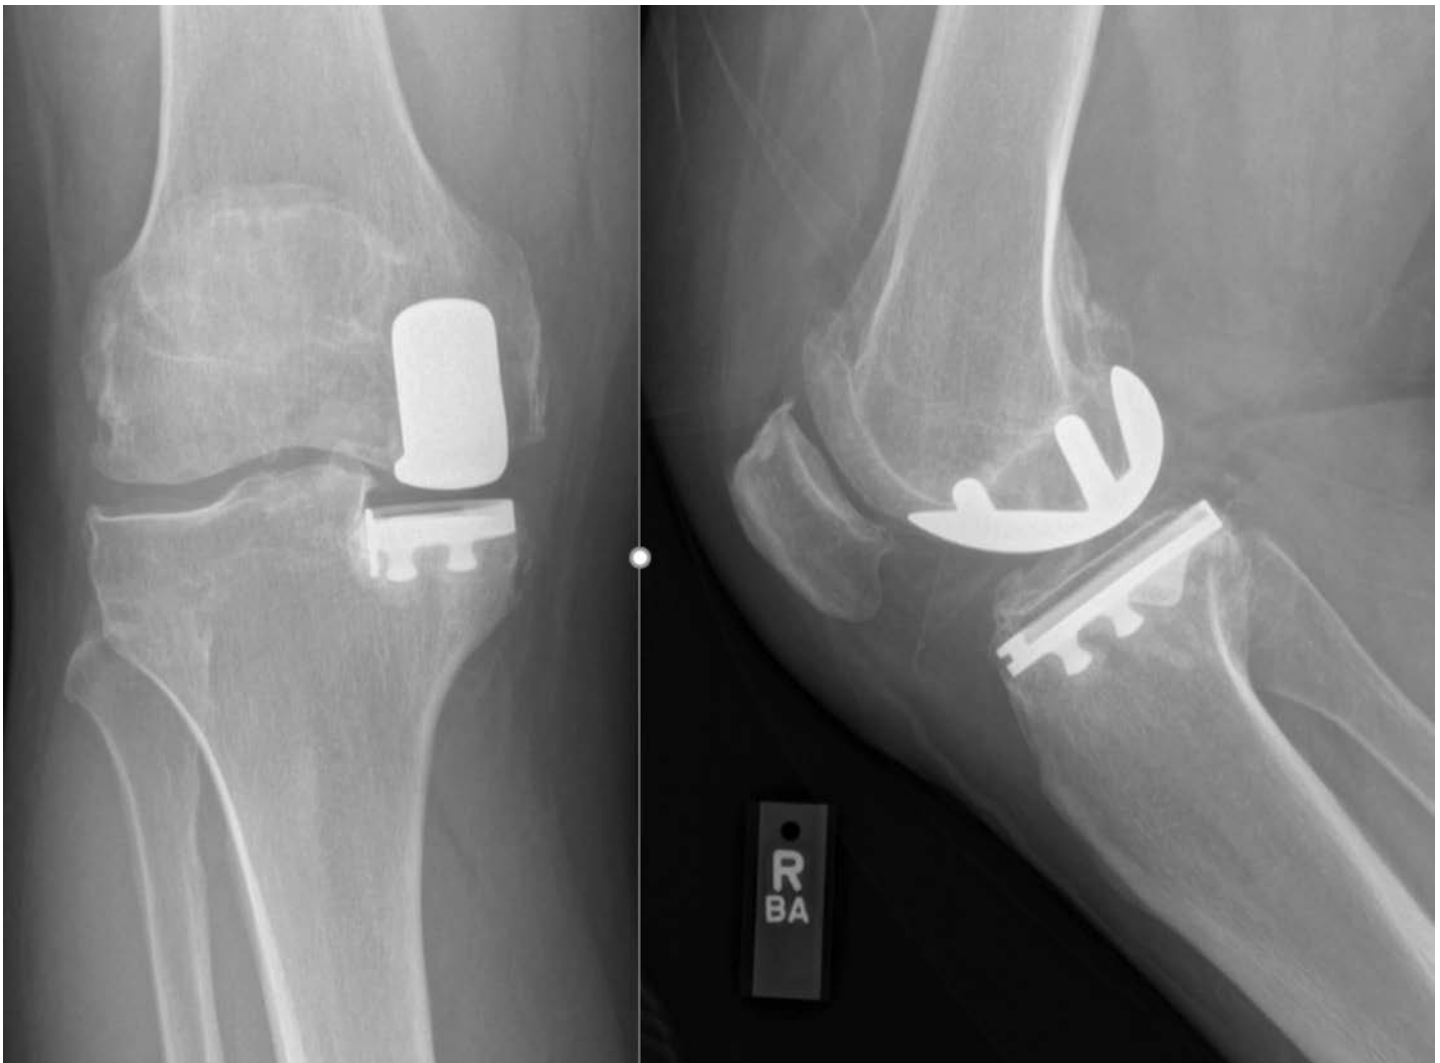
Post-operative AP and lateral view radiographs of the patient shown in Figure 24, after medial UKA.
